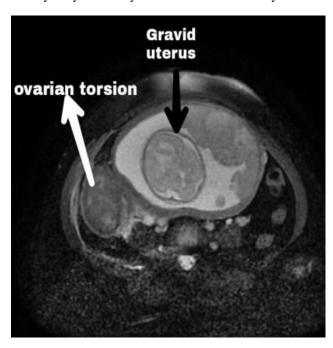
MRI image of gravid uterus along with ovarian torsion in sagital and axial view.
